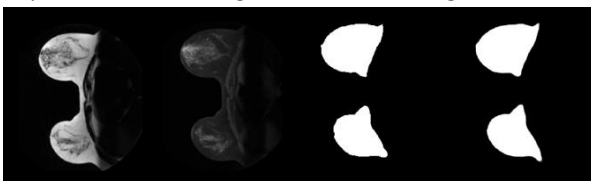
Example of U-Net output (right) relative to manual (center-right). Also shown are the fat (left) and water MRI data (center-left)
